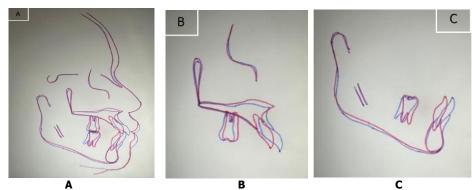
A. Superimposition of lateral cephalometric radiographs before treatment (blue line) and after treatment (red line); B. Superimposition of the maxilla before treatment (blue line) and after treatment (red line); C. Superimposition of the mandible before treatment (blue line) and after treatment (red line)
